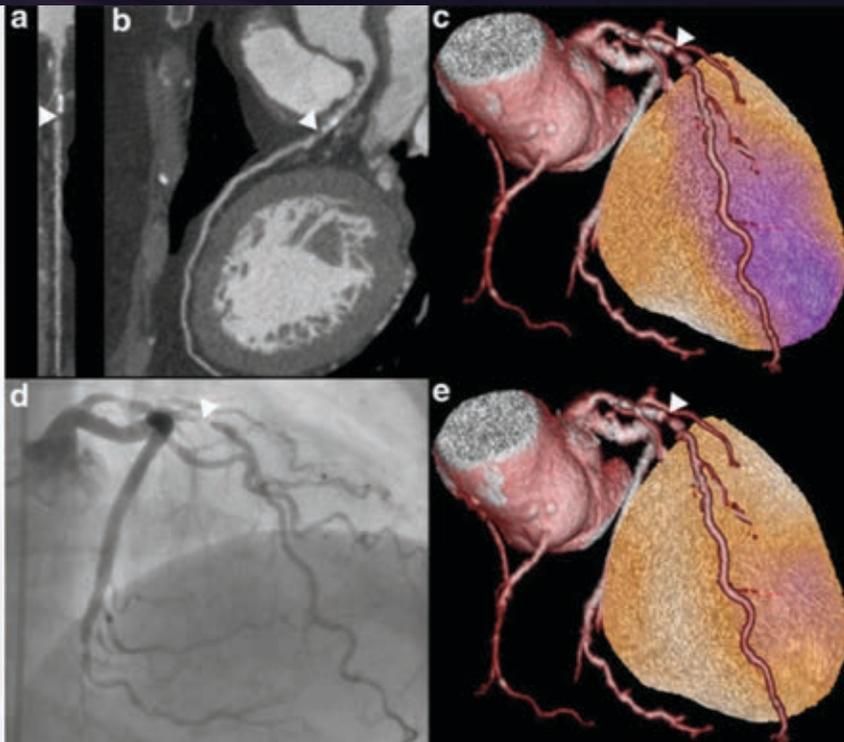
Cardiac image and angiographic findings. Coronary artery stenosis (white arrowhead) in the proximal left anterior descending artery is shown in the coronary CT angiography (a multiplanar and b curved multiplanar reconstruction), cardiac hybrid imaging with normal perfusion at rest (orange) and perfusion defect (pink/purple area) at stress (c), matching the territory of the coronary artery with stenosis (white arrowhead), and invasive coronary angiography (d) confirming coronary artery stenosis (Reproduced with permission from Professor P Kaufmann, University Hospital, Zurich).
